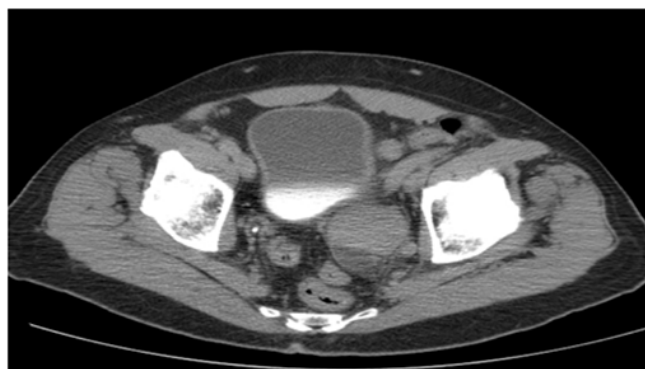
A CT scan of the pelvis of the same patient obtained on 5-18-2010. The radiologically defined tumor had grown, such that its widest diameter was now approximately 7 cm. The tumor was compressing the patient’s bladder. The Salicinium was discontinued and the patient was begun on Enercel.
